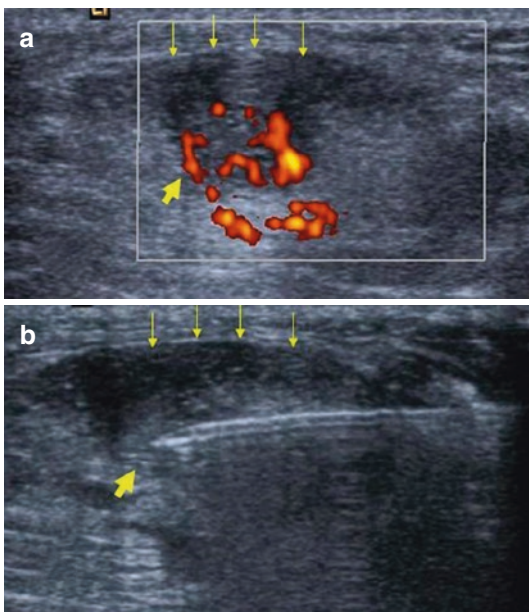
(a, b) US images (Doppler and B-mode, respectively) of an area of patellar tendon tendinopathy. (a) The tendon (*thin arrows*) is imaged in short axis, and the target area (*thick arrow*) corresponds to an area of neovascularity. (b) The needle is inserted axially to the tendon into the target area, and dry needling is performed by multiple punctures into the tendon
